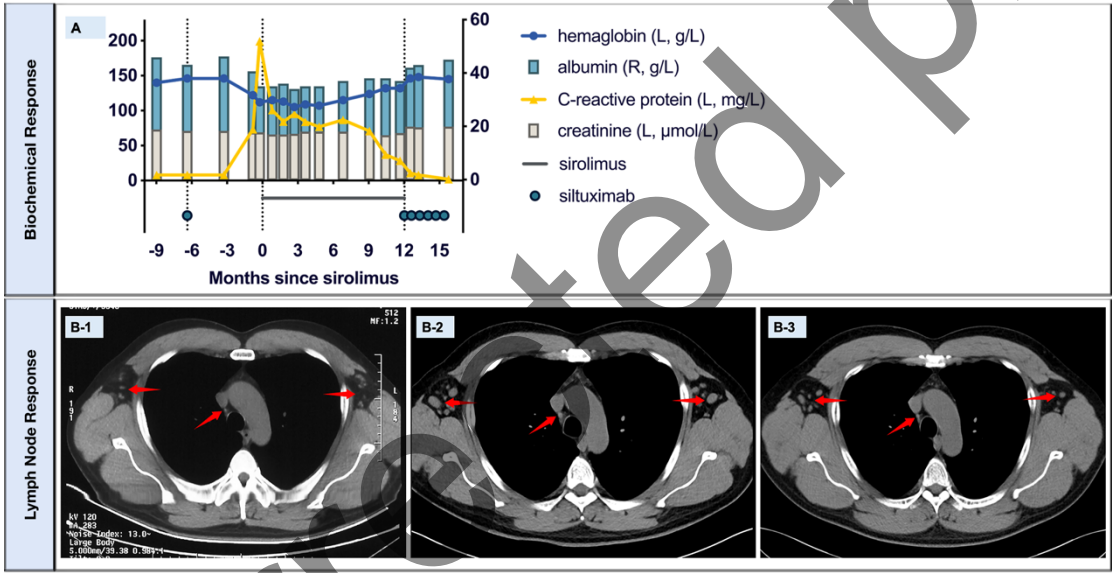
Individual laboratory measures at various time points (A). The three dashed lines represent the last administration of siltuximab in the initial phase, the first administration of sirolimus, and the first re-administration of siltuximab, respectively. The units and the corresponding Y axis are in notes at the right labels. R, right Y axis; L, left axis. Computed tomography (CT) shows the manifestations of lymph nodes 9 months prior to disease progression (B-1), during disease progression (B-2), and after six courses of siltuximab administration (B-3). At the last follow-up, the patient's lymph nodes had shrunk significantly, allowing for a full recovery of his physical fitness to the extent that he was capable of completing high-intensity fitness exercises, with a notable increase in his skeletal muscle mass evident in CT scans.
